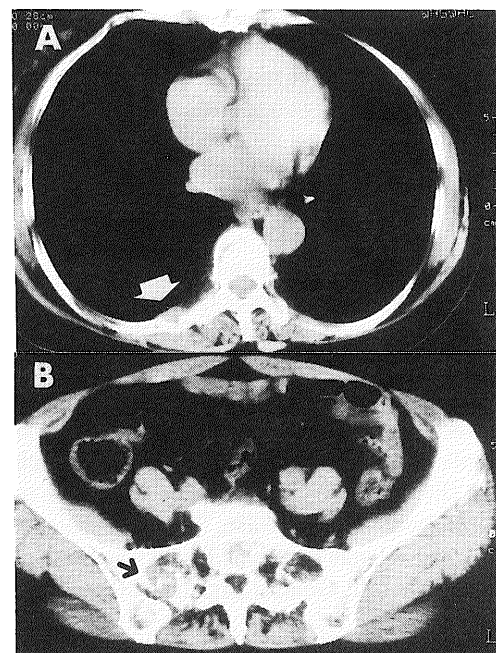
X-ray CT shows osteolytic changes in the right sacroiliac joint (black arrow, B) and the right rib with a surrounding small soft tissue density mass (white arrow, A). To our great surprise, the thoracic vertebral lesion is very faint on the CT image.
